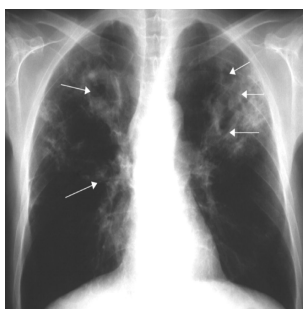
Chest radiograph showing extensive cavitory tuberculosis (arrows). Source: <https://erj.ersjournals.com/content/42/1/5>
